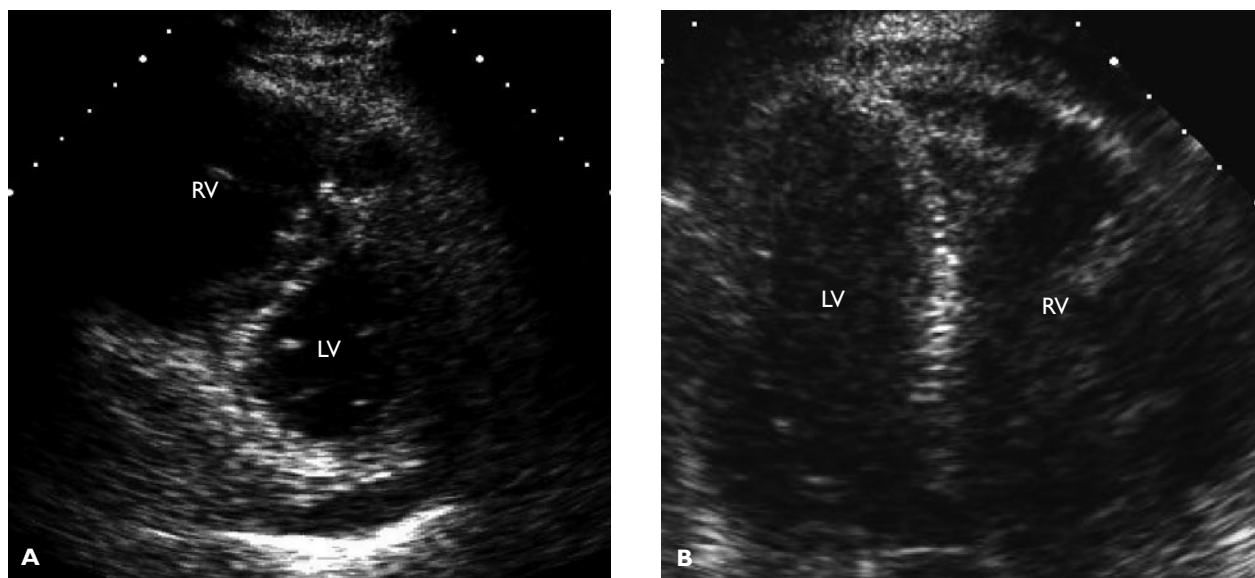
(A) A parasternal long-axis echocardiogram demonstrating a small left ventricle (LV) with a D configuration due to flattening of the interventricular septum and high right-sided pressures. (B) A 4-chamber-view echocardiogram demonstrating an enlarged right ventricle (RV).
